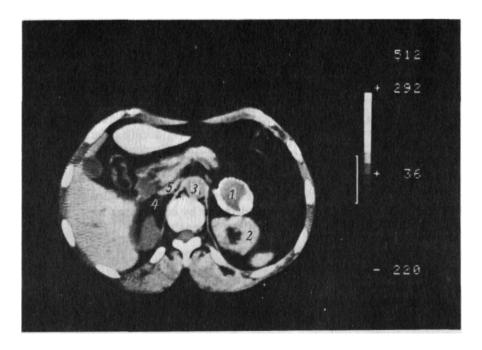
CT scan of a patient with tumour of the left adrenal gland.
